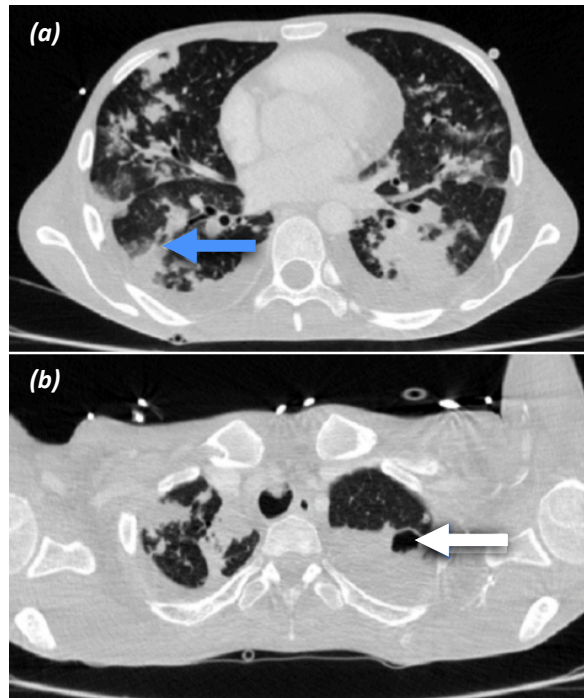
(a) CT chest showing the septic embolus (blue arrow) and the pleural effusion as well as (b) a cavitary lesion in the left upper lobe (white arrow)
